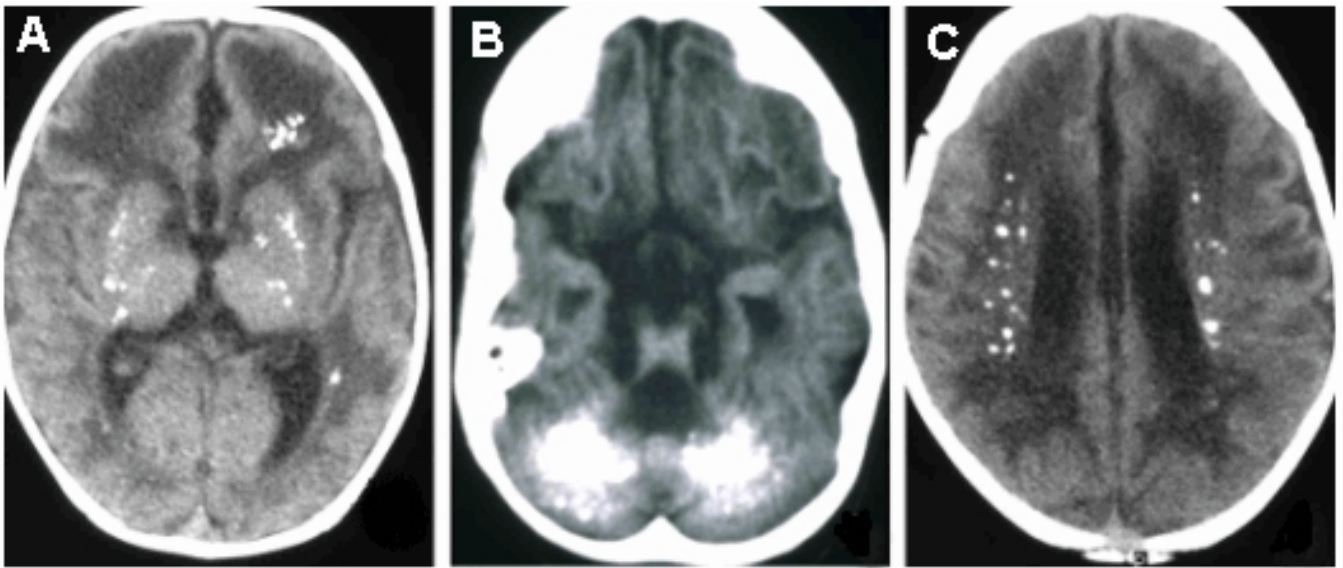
Examples of intracranial calcification on CT scan in individuals with AGS. Calcification is seen in the basal ganglia (panel A), in the dentate nuclei of the cerebellum (panel B), and in a periventricular distribution (panel C). Figure originally published in *The American Journal of Human Genetics*, University of Chicago Press, October 2007.
